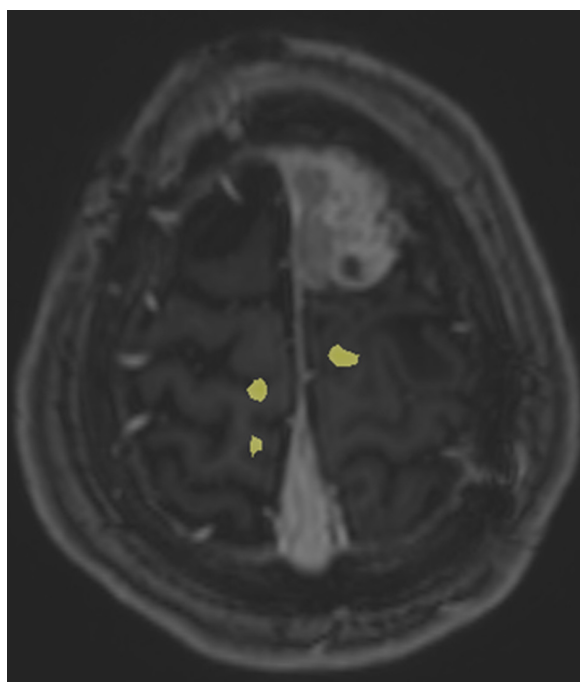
Functional magnetic resonance image of the foot motor task showed cortical activation in the medial part of left precentral gyrus (yellow colour). Residual enhancing tumour is seen in the left frontal region.
